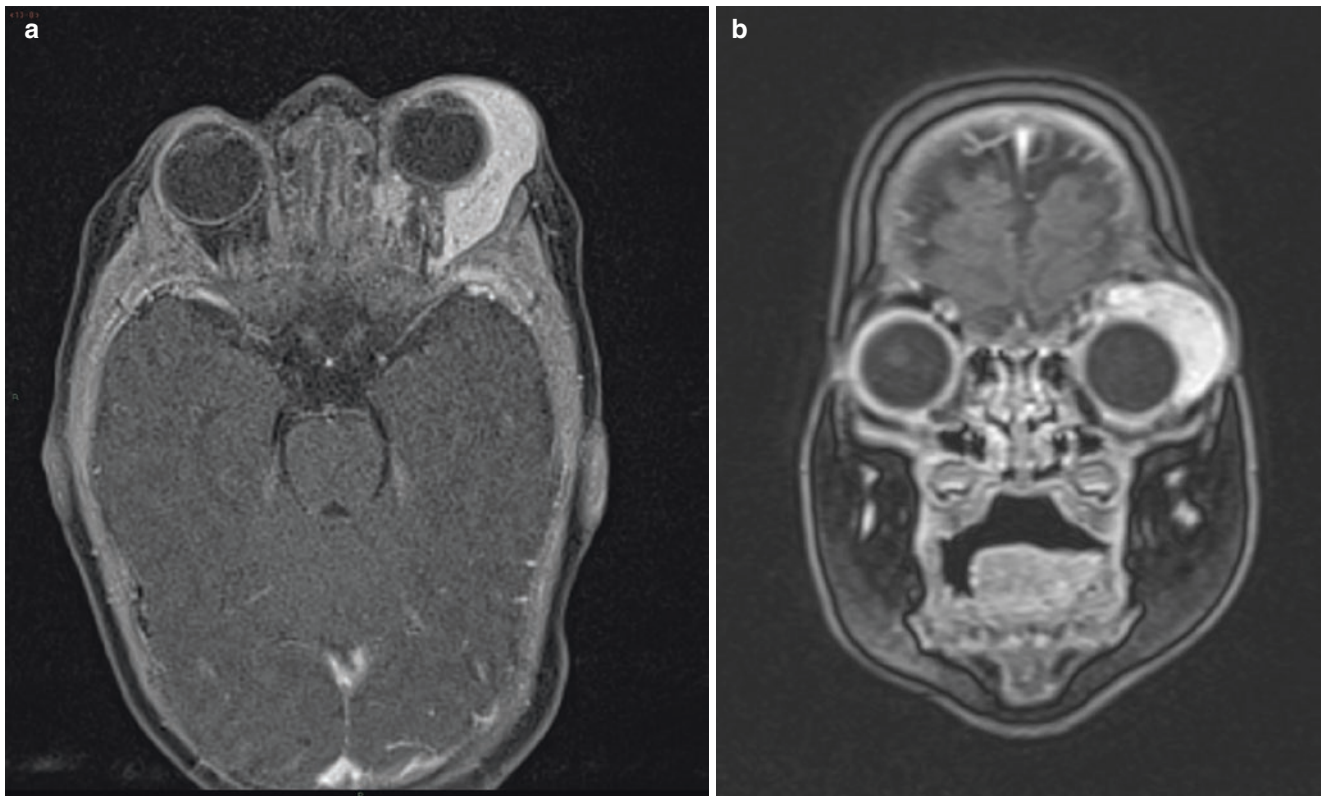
Axial (a) and coronal (b) post-contrast T1-weighted fat-saturated MR images show avid enhancement of a left intraorbital haemangioma
